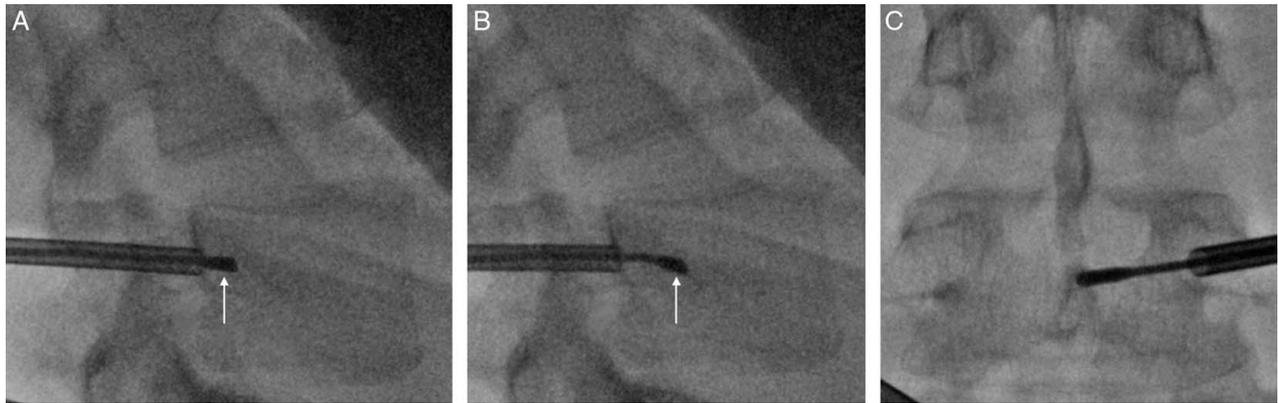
A, Lateral x-ray with the J-stylet of the curved cannula assembly beginning to exit the introducer cannula into the vertebral body at L5. B, Lateral x-ray view with J-stylet starting to curve medially, known as foreshortening. C, AP x-ray with the J-stylet approaching midline at L5.
